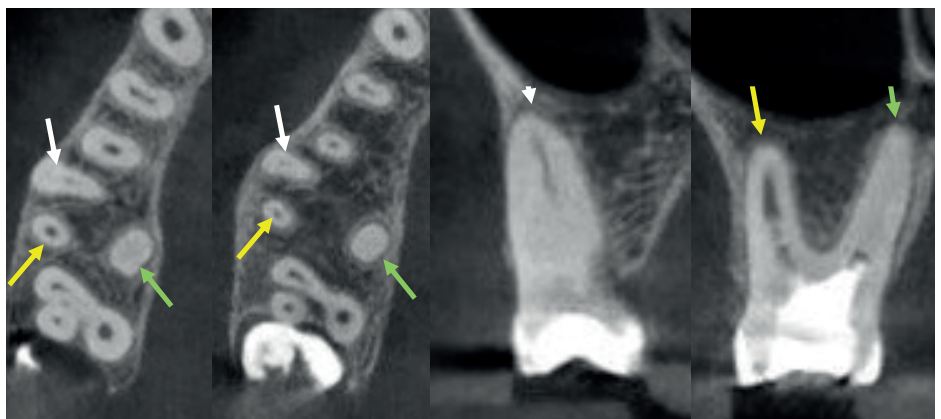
High resolution CBCT images at a 5-year follow-up visit depicting the new root canal anatomy: (a) Axial view at the level of the coronal third of the roots showing a partially obliterated mesiobuccal root canal (white arrow), completely obliterated palatal root canal (green arrow) and patent distobuccal root canal system (yellow arrow); (b) Axial view at the level of the apical third of the roots also showing a partially obliterated mesiobuccal root canal (white arrow), completely obliterated palatal root canal (green arrow) and patent distobuccal root canal system (yellow arrow); (c) Coronal view of the mesiobuccal root showing partially with a closed apex (white arrow). Note the coronal calcification of the root canal system with only some canal system visible towards the apical third of the root; (d) Coronal view of the distobuccal (yellow arrow) and palatal (green arrow) roots with closed apices. Note the patent distobuccal root canal system with evidence of pulp calcification in the midroot area of the canal. The entire palatal root canal system was calcified.
